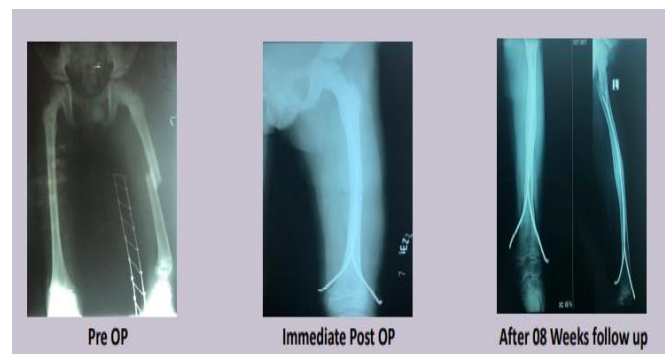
Preoperative and postoperative x-ray findings
